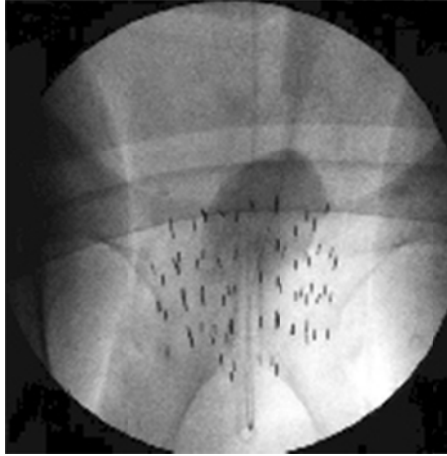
X-ray of radioactive seeds during the prostate brachytherapy procedure [11]
